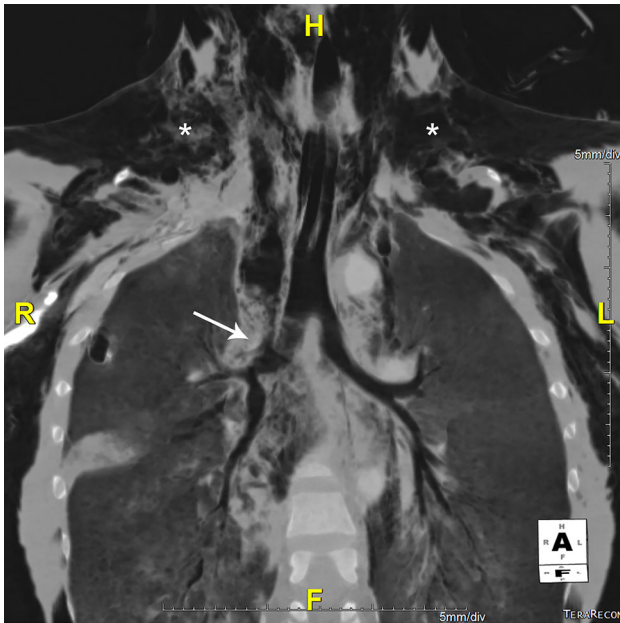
This coronal minimum projection image (Minip) demonstrates irregularity of the right main stem bronchus (arrow) when compared to the left. There is extensive soft tissue, mediastinal and subcutaneous emphysema (asterisks) bilaterally but worse around the right main bronchus and right paratracheal soft tissues. Frothy material is also seen in the right main stem bronchus. A right bronchus injury was diagnosed by CT and confirmed at surgery. Characteristics of this uncommon injury include the extensive soft tissue air that dissects through the mediastinum and into the subcutaneous soft tissues
